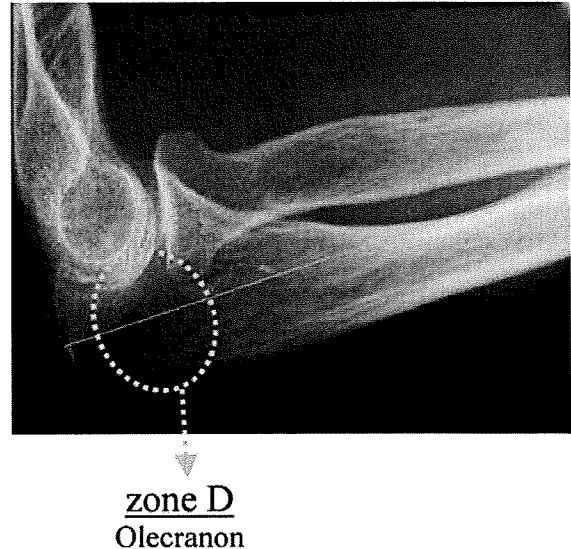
Radiographic classification (zone D)
